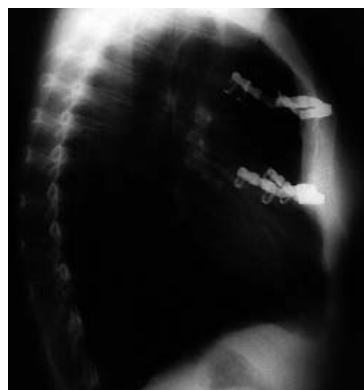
X-ray of profile after correction of the pectus arcuatum.
